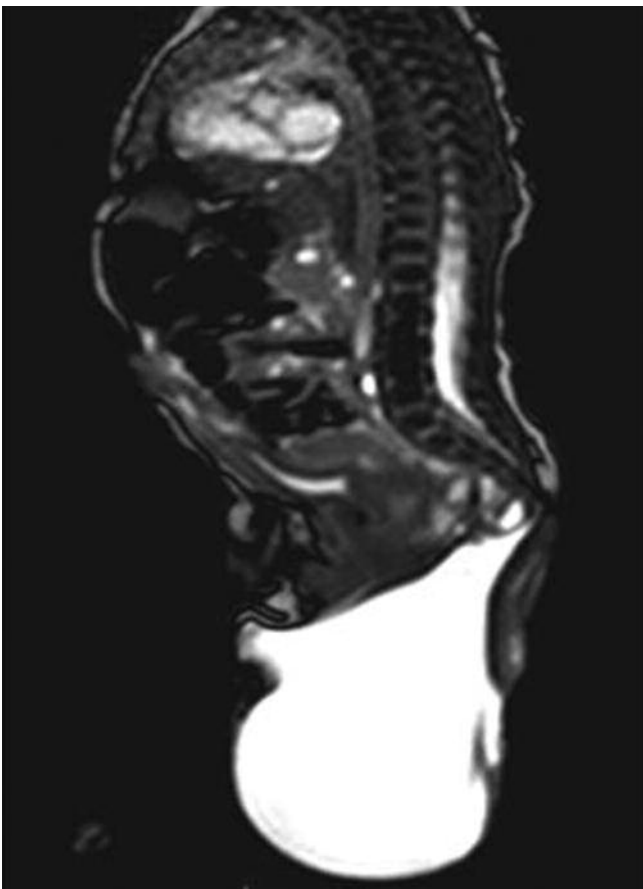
Post natal MR imaging showing the mass and the integrity of the sacrum.
